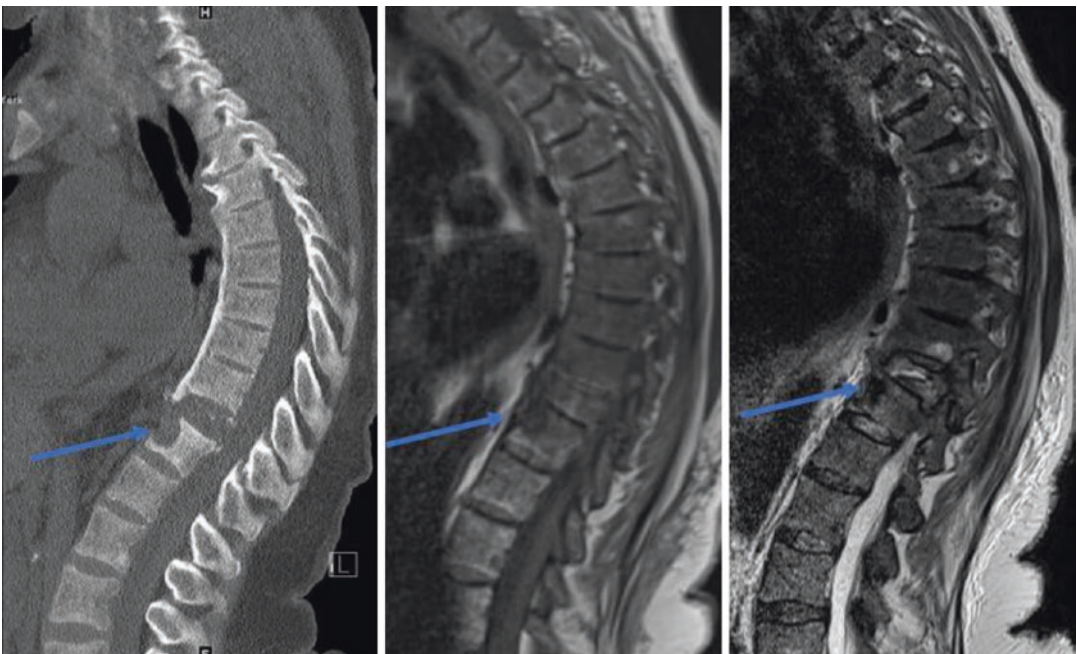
Sagittal CT, T1-, and T2-weighted images demonstrating a brown tumor (arrows) involving the anterior aspect of the T12 vertebral body with significant collapse
